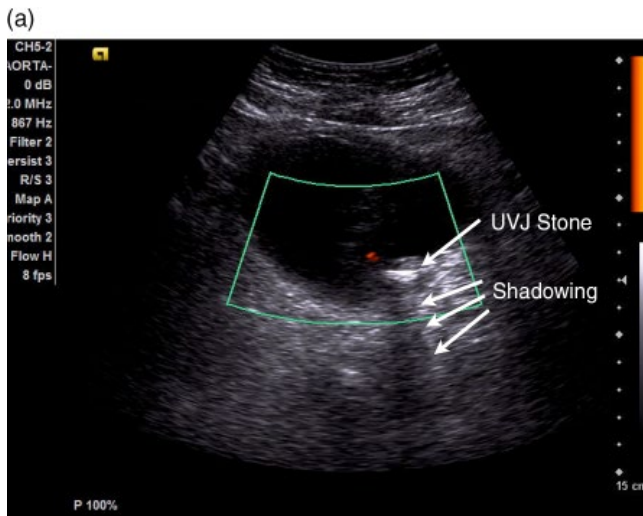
(a) Recognition of shadowing in the region of the left ureterovesical junction (UVJ) led to identification of this UVJ stone. (b) Edge artifact (lateral cystic shadowing) is an artifactual finding which might easily be mistaken for a stone impacted in the gallbladder (GB) wall or neck. Sonographic interrogation in multiple planes can help confirm that the finding arises from the edge and not from within the GB.
